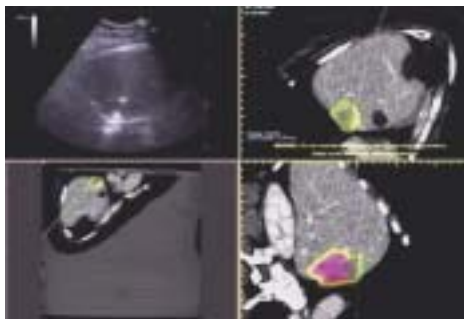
Percutaneous RFA treatment of large metastatic lesion poorly visualized by ultrasound. Treatment is guided using real-time US/CT image fusion. On CT scans the lesion has previously been mapped with colours. The peripheral "safety halo" is marked in yellow. Due to the large size of the mass, treatment requires multiple electrode insertions: after each insertion, the colour map is removed in the corresponding volume of tumour ablated in order to make the still unablated portions clearly visible.
